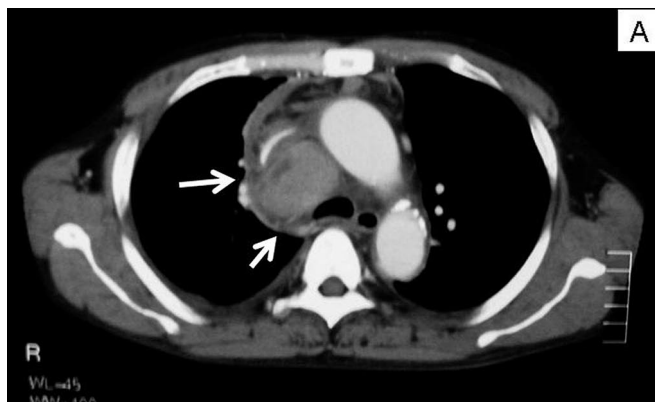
Computed tomographic scan demonstrates a large mass in the upper mediastinum (arrows). *A*, The superior vena cava is narrowing and has become crescent-shaped because of the mass, but no superior vena cava syndrome is seen. *B*, The mass is located among the superior vena cava, trachea, and ascending aorta.
